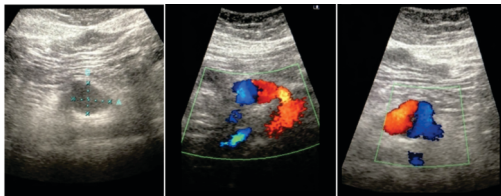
abdominal ultrasound (gray scale and Doppler) images shows aberrant splenic artery arises from SMA (splenomesenteric trunk)
